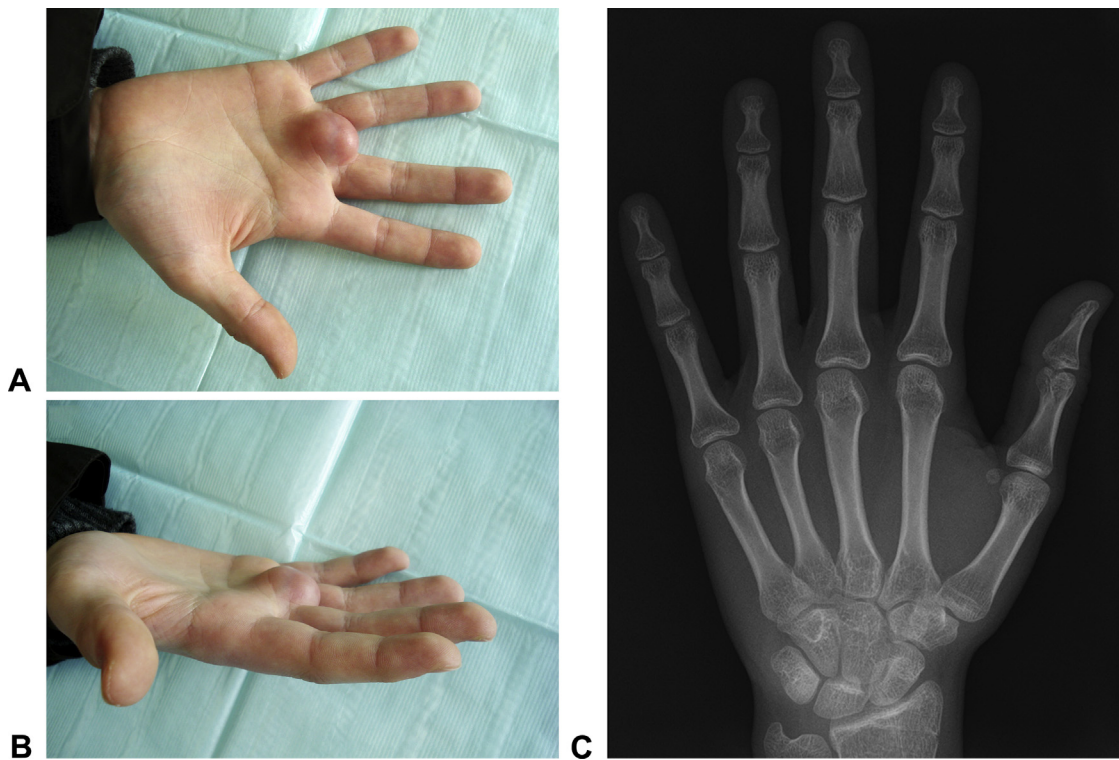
A, B Clinical appearance of the subcutaneous mass. C Conventional x-ray.
